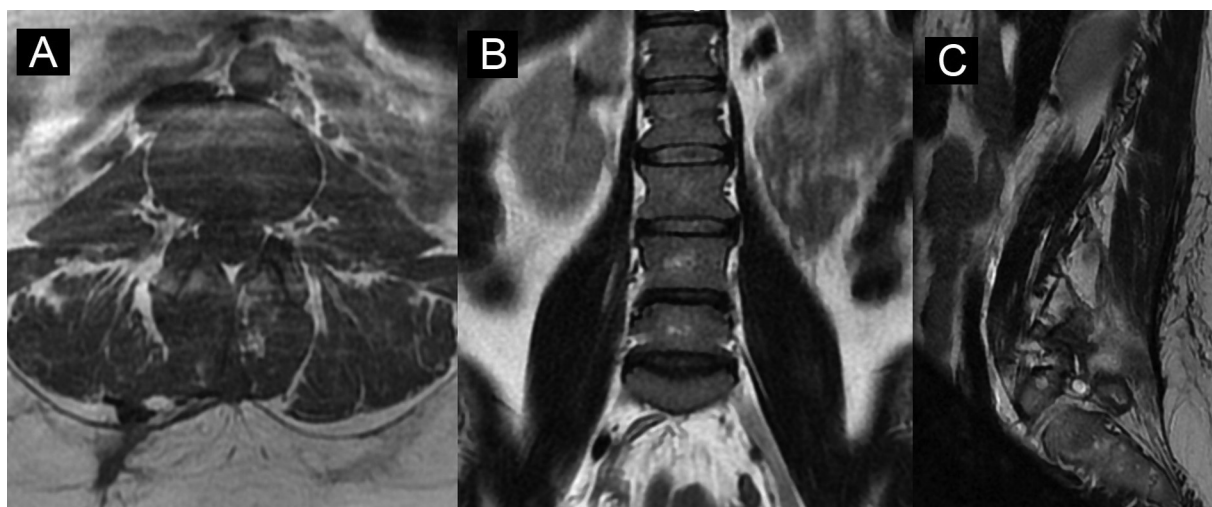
Lumbar postoperative spine MRI: (A) axial, (B) coronal and (C) sagittal reconstructions show total removal of the tumor.
